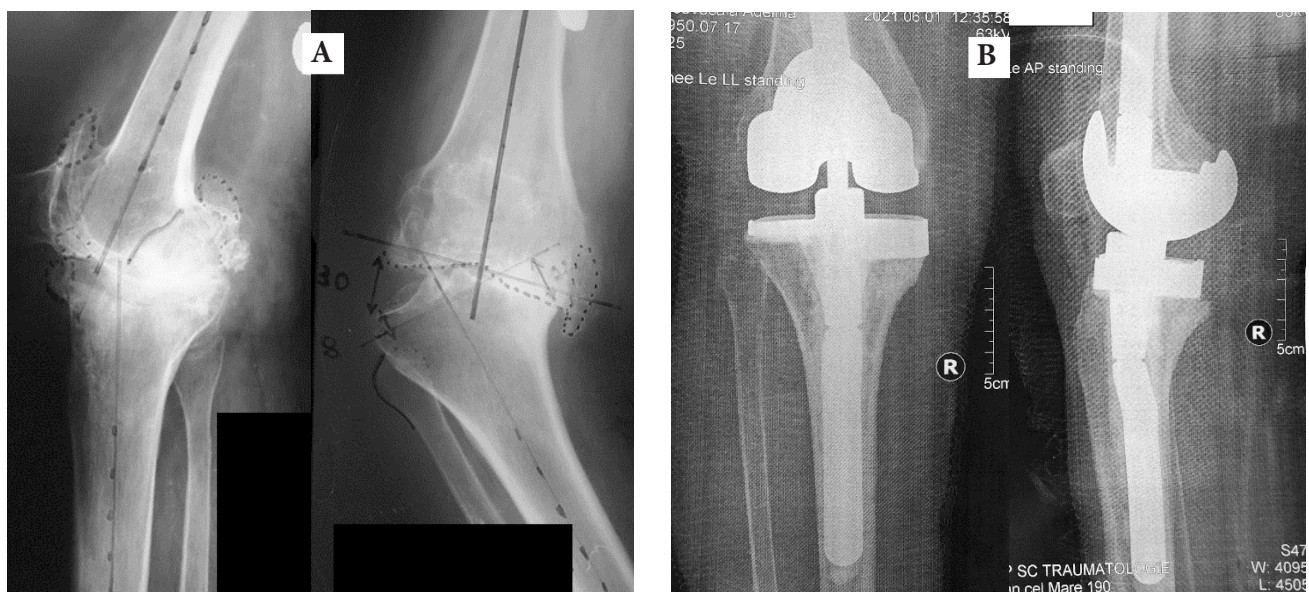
CKP with augmentation on medial plateau implanted in a 70-year-old woman because of 28° varus deformity of the right knee. A – Pre-operative radiographs, B – Radiographs after surgery
